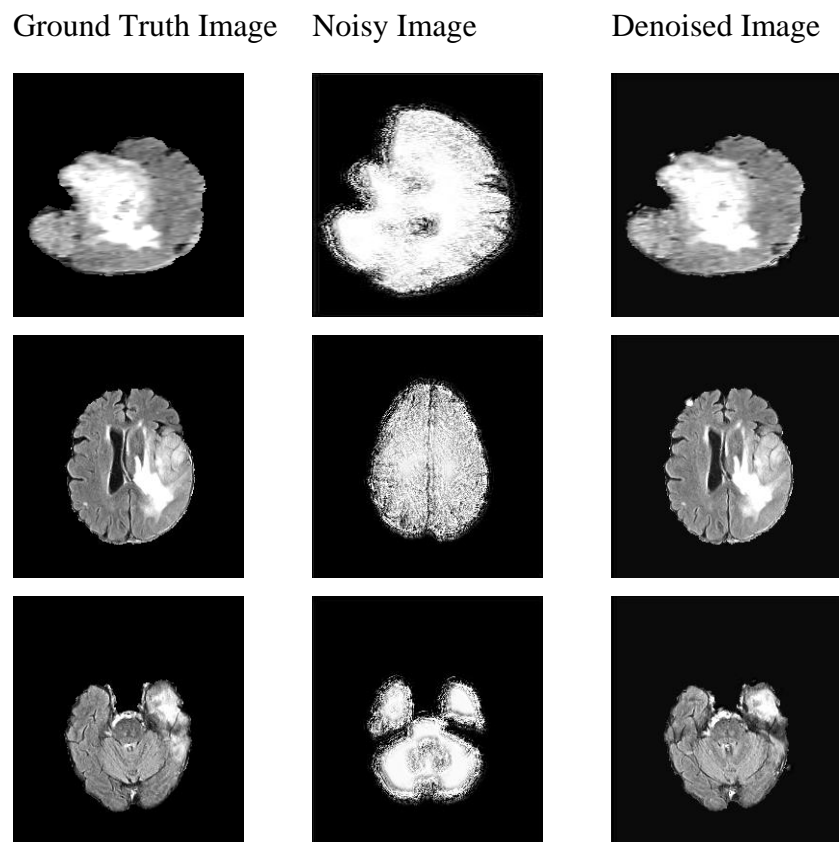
Denoising of MRI images using MTCL
